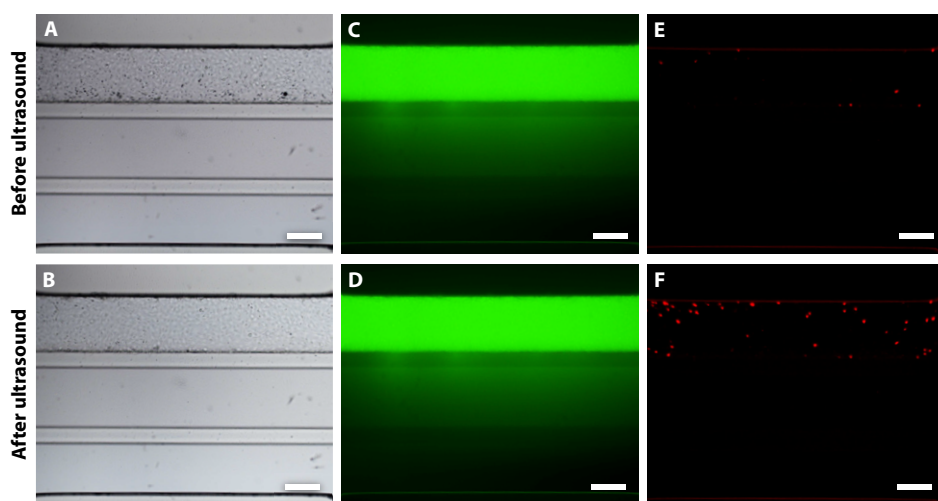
Microbubble-mediated drug delivery in 3D microvessels cultured in the OrganoPlate uponinsonification with a 2 MHz, 400 kPa, 5×10 -cycle burst. The brightfield images show the channel structure and microbubbles (small black dots) that are present (A) before and (B) after ultrasound. The fluorescent 150 kDa FITC-dextran images show diffusion from the top channel into the gel channel (C) before and (D) after ultrasound. The fluorescent PI images show the uptake of model drug in membrane disrupted cells (E) before and (F) after ultrasound. Scale bars are 200 μm .
